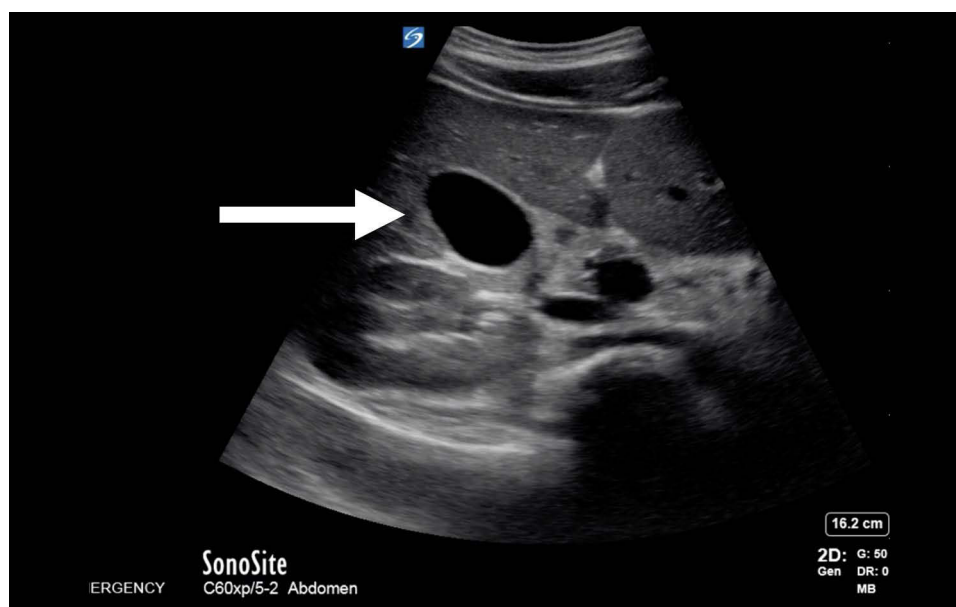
Normal sonographic appearance of the gallbladder on ultrasound. Arrow denotes gallbladder.
